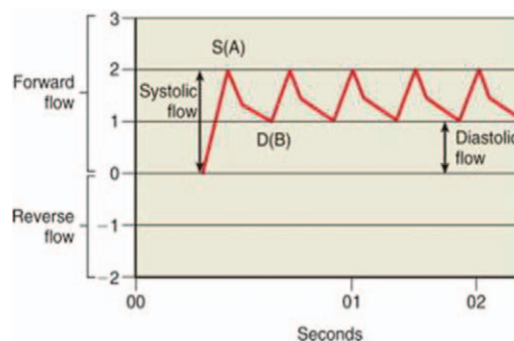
Umbilical artery Doppler velocimetry. Normal umbilical artery Doppler velocity waveform. Flow is forward during both systole and diastole. (A) = S for peak systolic frequency shift; (B) = D for peak end diastolic frequency shift. This figure is adapted from Druzin.¹¹
